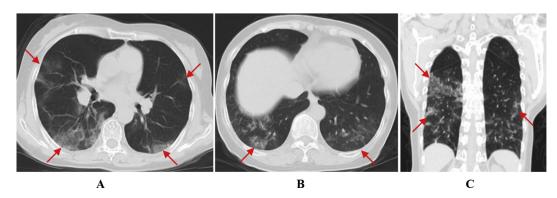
Chest CT findings in a 70-year-old woman with COVID-19 A, B. Chest CT axial and coronal images reveal multiple ground glass opacities (GGO) seen subpleurally and in the middle and lateral bilateral lung fields (red arrows). They are especially pronounced in the right lung, where they have partially fused into patches (red arrows), local interlobular septal thickening is also observed C.
